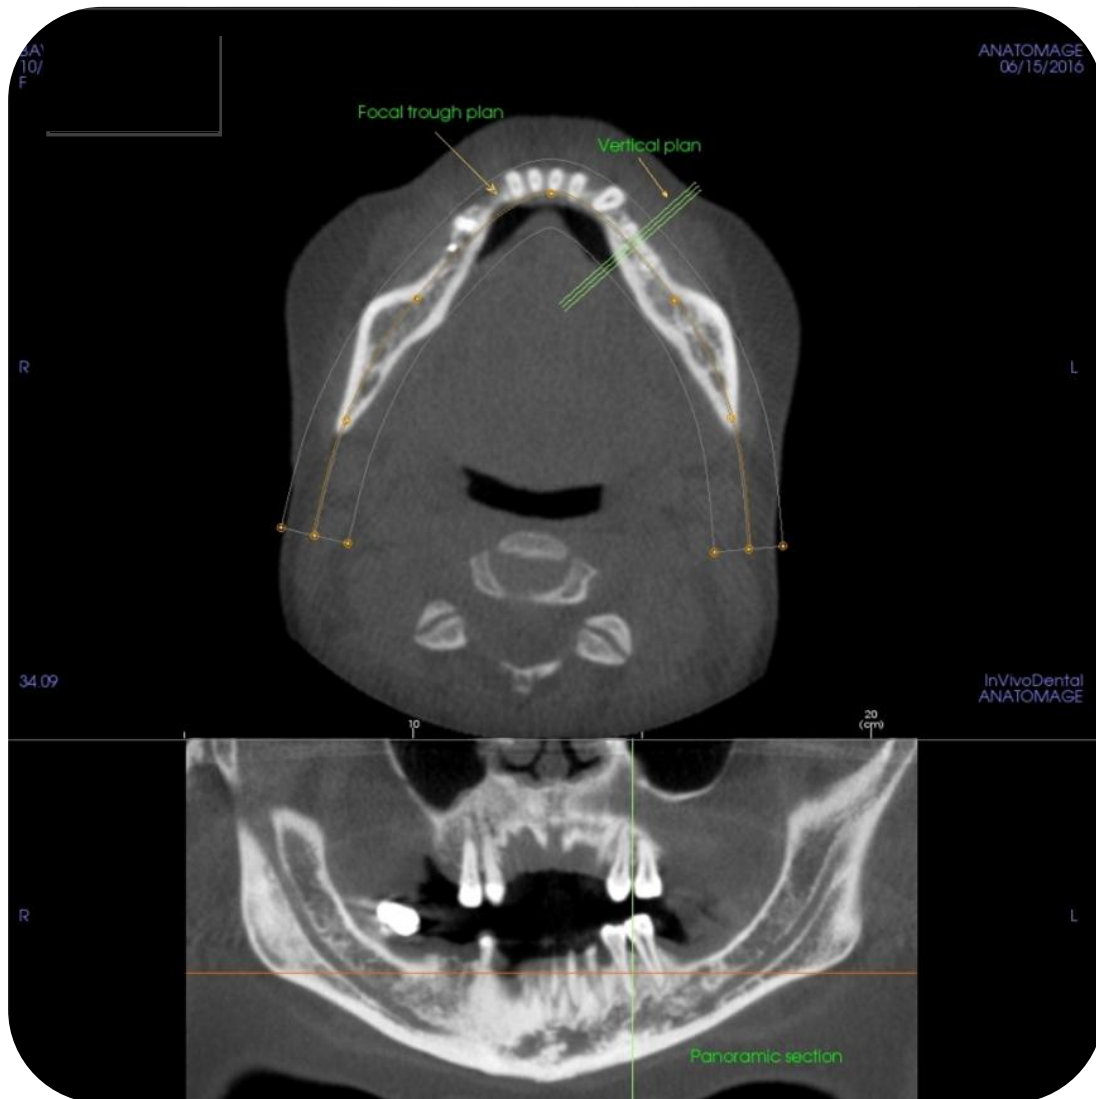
The Arch Section option (cropped); Above: The axial section showing the focal trough plan and vertical plan. Below: The panoramic section with the same plans in different orientation (Images obtained with i-CAT® Model 17-19; CBCT Imaging Unit: InVivoDental5 Version 5.2 Anatomage, software); Dentomaxillofacial Radiology Department; Faculty of Dentistry- University of Yeditepe.
